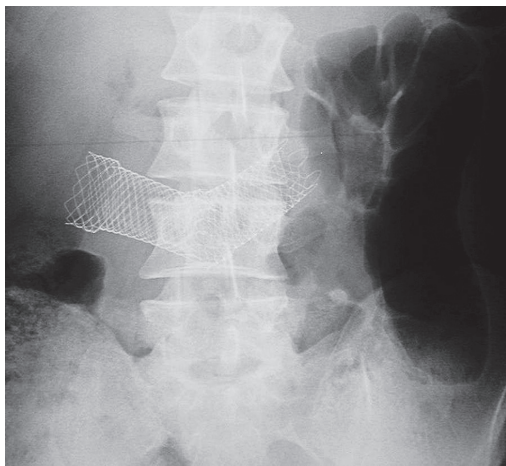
Abdominal X-ray showing the two overlapping self-expandable metal stents a few days after placement
